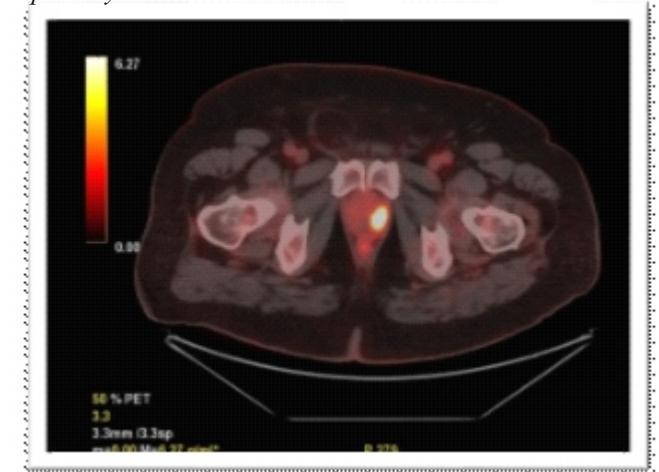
Axial FDG-PET/CT: Incidental avid prostate lesion (SUVmax 13.4), later diagnosed as intermediate-risk adenocarcinoma.
